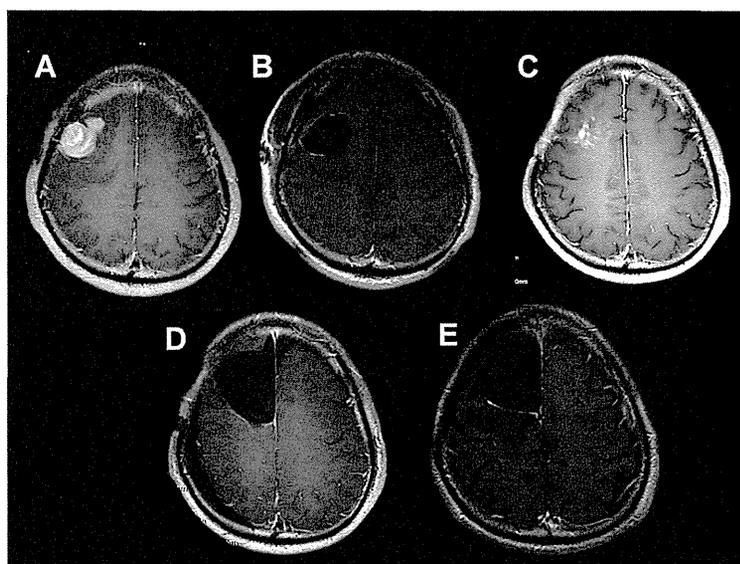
A: Preoperative axial contrast T₁-weighted magnetic resonance (MR) image of a patient with primary subventricular zone (SVZ)-negative glioblastoma (GBM). The contrast-enhanced lesion does not contact the SVZ. B: Postoperative axial contrast T₁-weighted MR image of a patient with primary SVZ-negative GBM. No residual tumor is observed on MRI. C: Five months after surgery, an enhanced lesion is evident around the resection cavity. D: Postoperative axial contrast T₁-weighted MR image of a patient with recurrent SVZ-negative GBM. No residual tumor is visible on MR imaging. E: Four months after surgery, an enhanced lesion around the resection cavity can be observed.
